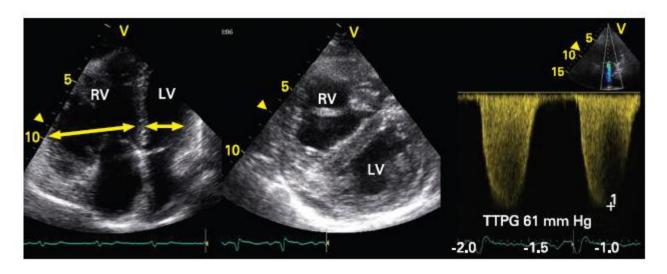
Echocardiographic examination of a patient admitted for a recurrent episode of pulmonary embolism. The right ventricle (RV) was enlarged compared with the left ventricle (LV) and the ratio between end diastolic RV to LV diameter was >0.6. The transtricuspid pressure gradient (TTPG) was notably increased, indicating severe pulmonary hypertension.
